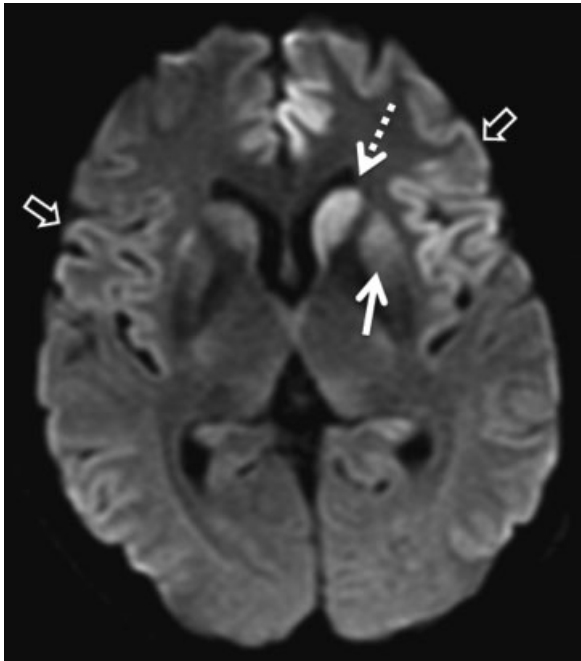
Diffusion-weighted imaging (DWI) magnetic resonance imaging in a 47-year-old patient with Jakob-Creutzfeldt disease demonstrating restricted diffusion (hyperintensity) of the caudate (dashed arrow) and putamen (solid arrow), as well as cortical ribboning (arrow outline). Orientation is radiological.
